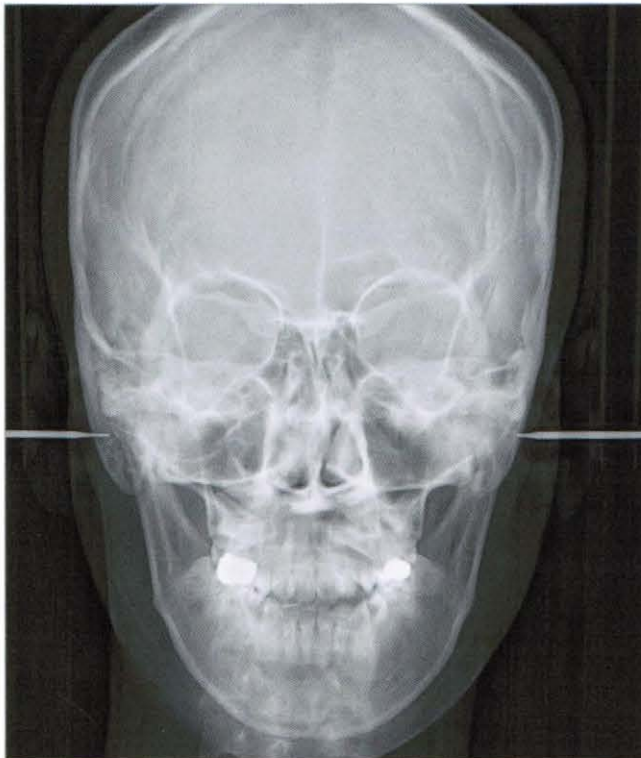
Pre-treatment postero-anterior radiograph. It shows no abnormalities.
